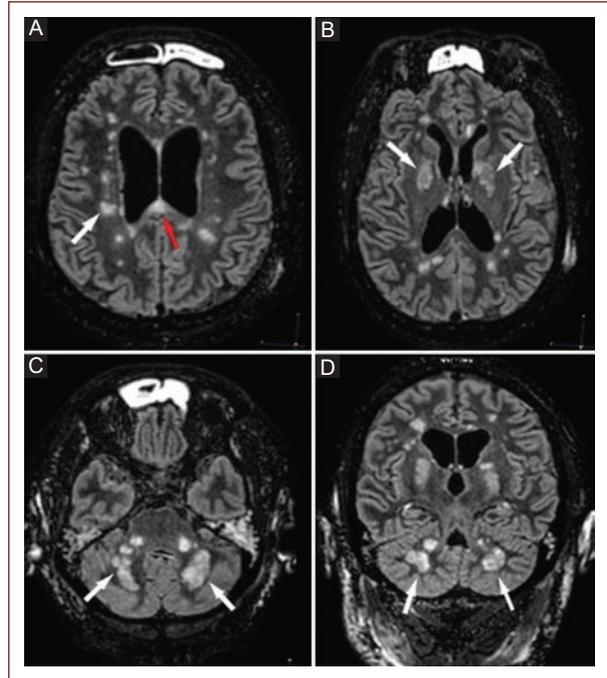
Axial (A, B, and C) and coronal (D) Flair MRI. Diffuse hyperintense images suggestive of ischemic lesions in basal ganglia and cerebellar peduncles.
